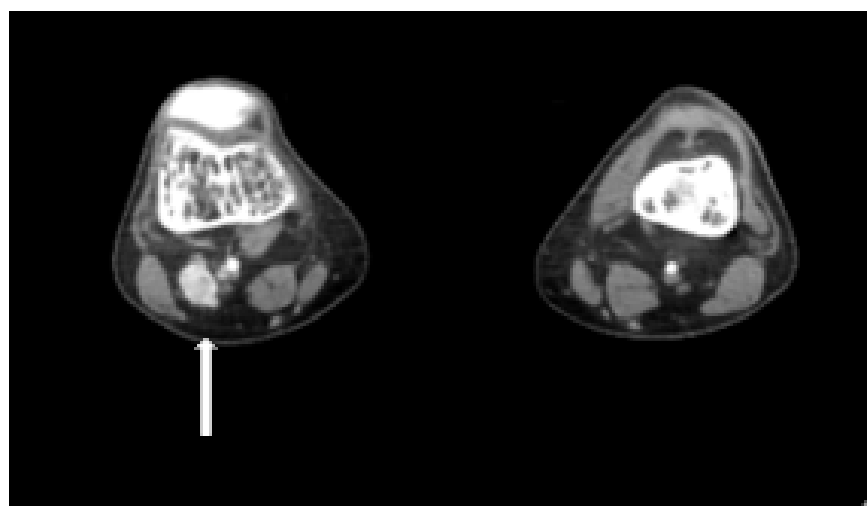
CT with IV contrast injection demonstrating enhancement of a small soft tissue mass in the popliteal fossa of the right knee, located adjacent to the lateral aspect of the popliteal vessels and the tibial nerve and medial to the common peroneal nerve.
